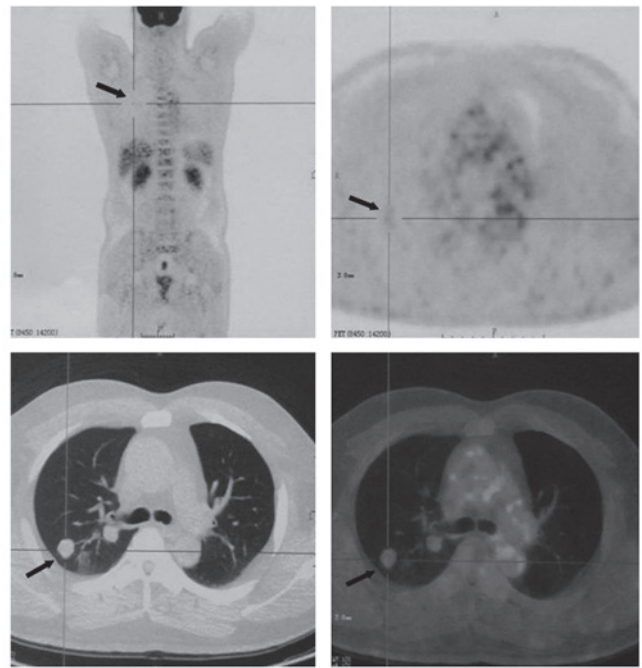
^{18}F -FDG PET/CT of the present case showing multiple lung nodules with mild ^{18}F -FDG uptake and a SUVmax of 1.19 for a nodule in the right lower lobe (arrow). ^{18}F -FDG PET/CT, ^{18}F -fluorodeoxyglucose positron emission tomography/computed tomography; SUV, standardized uptake value.
